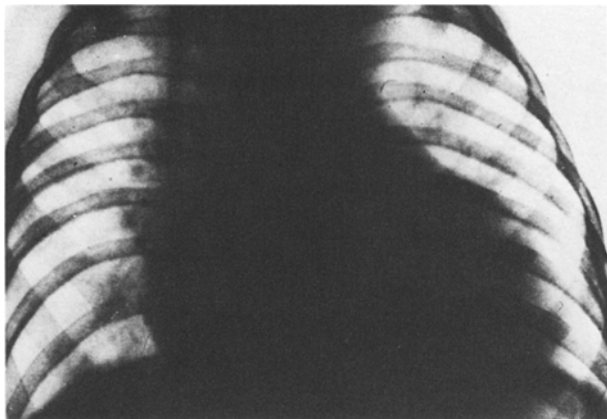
Postoperative chest x-ray film showing reduction of cardiomegaly.
